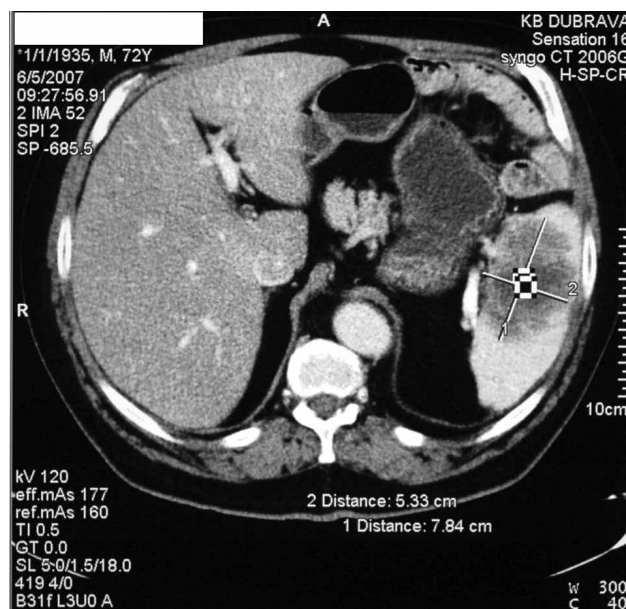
Abdominal CT scan showing hypovascular splenic lesion.
